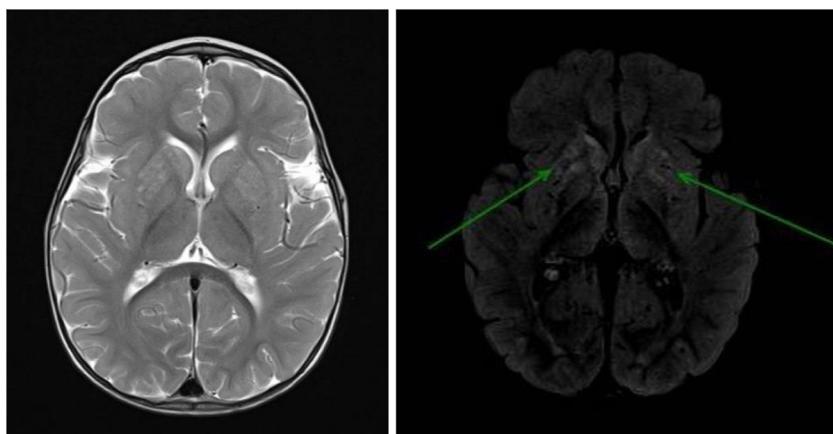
Brain MRI scan: bilateral signal alterations in the putamen and head of the caudate nucleus; hyperintense lesions on T2-weighted (left) and FLAIR sequences (right: arrows). No globus pallidus or internal capsule involvement were observed. No loss of parenchymal volume was observed at the supra- or infratentorial levels.
